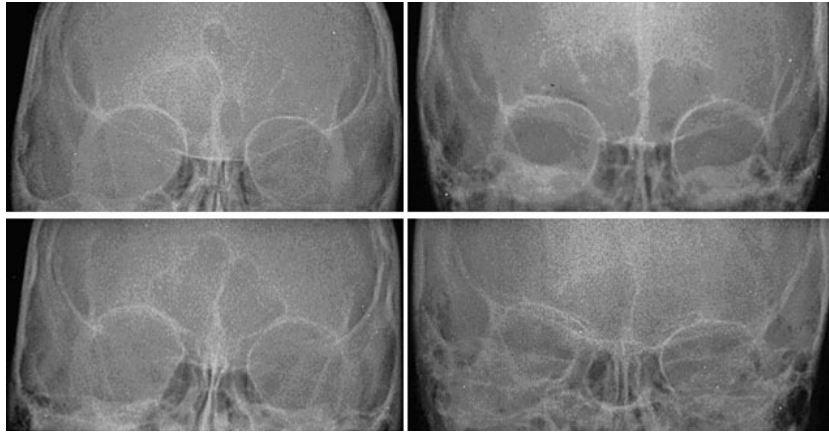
Antero-posterior radiographs of frontal sinuses of four individuals belonging to same family.
